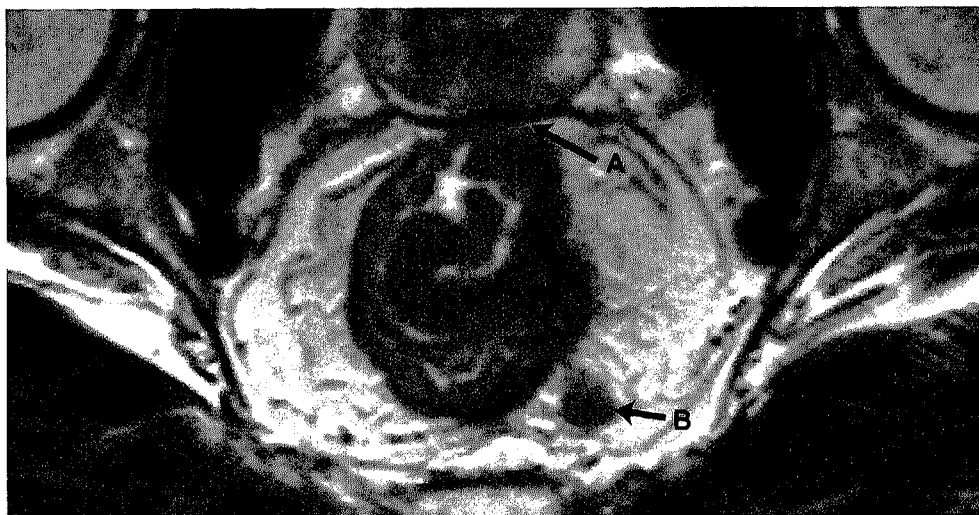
T3 rectal cancer with an involved CRM with a tumor deposit in a 44-year-old male patient. Coronal T2W FSE (TR/TE 3427/150 msec) MR image shows a tumor in the rectal wall. This figure shows both most important prognostic factors. Anteriorly the tumor minimally invades the mesorectal fascia (A). In addition, a tumor deposit is seen in the mesorectum (B).
